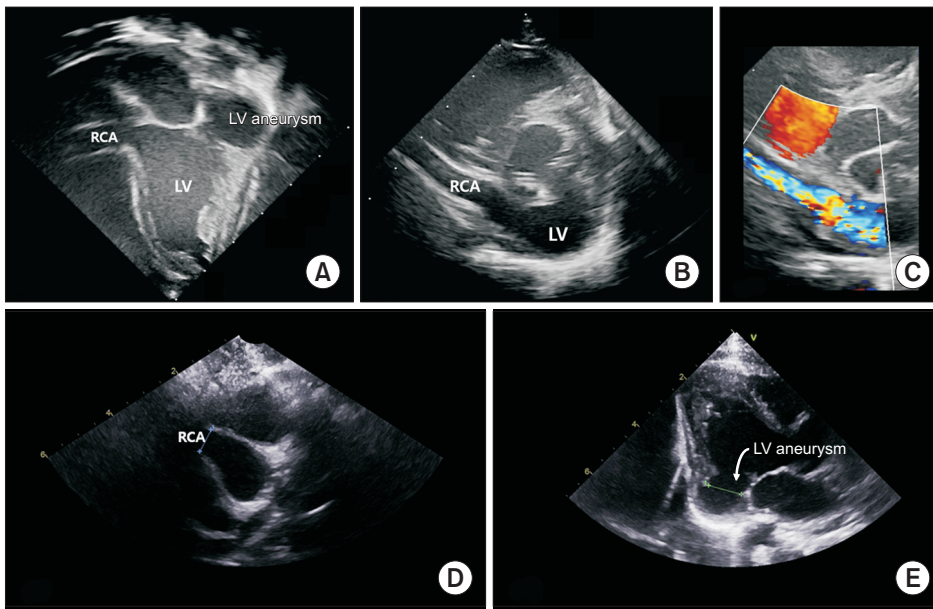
(A–C) Preoperative transthoracic echocardiography. (A) The apical 4-chamber view shows a dilated right coronary artery (RCA) and left ventricle (LV) aneurysm. (B) The parasternal short-axis view shows the distal RCA draining to the base of the LV. (C) Color Doppler image visualizing the direction of blood flow from the distal RCA to the LV. (D, E) Postoperative transthoracic echocardiography at a 4-month follow-up. (D) In the parasternal short-axis view, the proximal RCA was measured as 6.28 mm. (E) In the apical 4-chamber view, LV aneurysm was measured as 11.3×8.1 mm (arrow).
